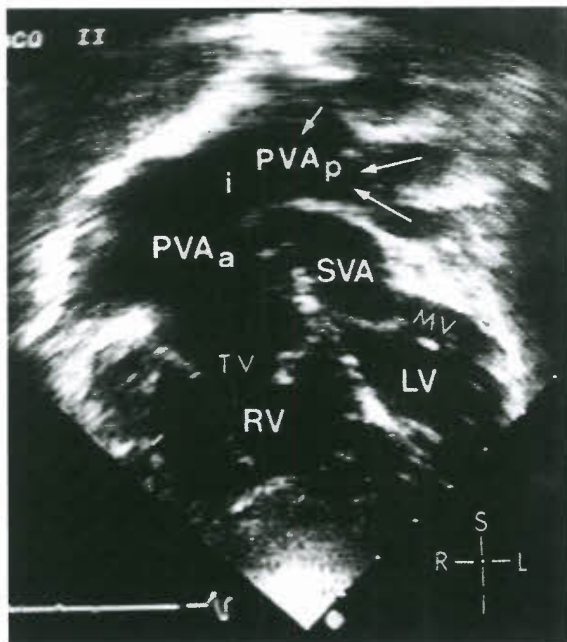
Two-dimensional echocardiogram (subcostal view) in 8-year-old with TGA/IVS with Mustard repair at 1 year of age. Note reconstructed pulmonary venous atrium (PVA) compartmentalized into posterior segment (PVA_p) with left pulmonary venous drainage and anterior segment (PVA_a) with tricuspid valve. Note wide unobstructed isthmus (i) between PVA_p and PVA_a, and pericardial baffle separating PVA from systemic venous atrium (SVA). TV, tricuspid valve.
